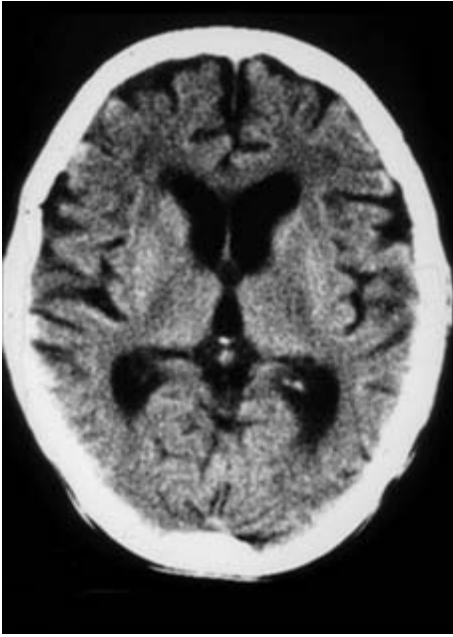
Axial computed tomography (CT) scan of a patient with Alzheimer's disease demonstrating mild diffuse cerebral atrophy.
